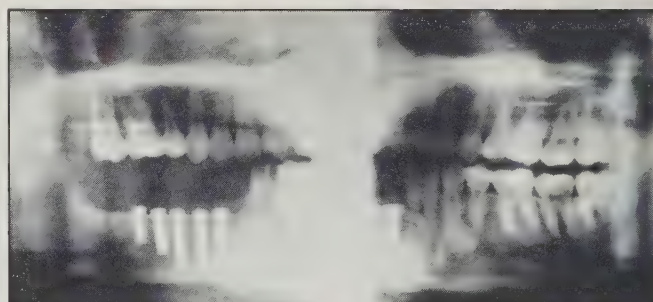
One year post-surgery radiograph. Five Bränemark titanium dental implants in the microvascular iliac crest graft to the mandible. The mucosa is closed and the implants nonloaded for six months to allow osseointegration to occur.
